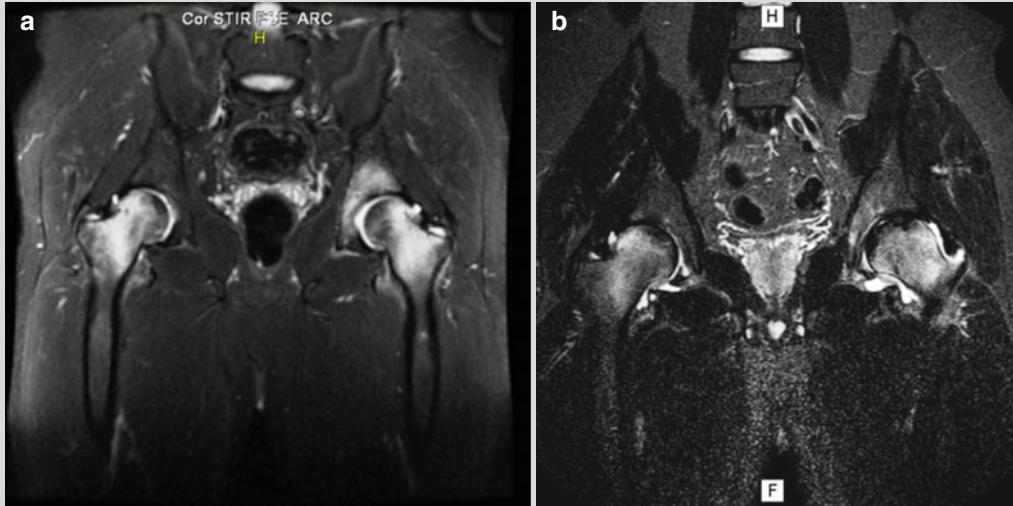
(a) Notice the left-sided acetabulum and proximal femur regions' bone marrow edema (fat-suppressed T2-weighted coronal image). This scan was obtained at the beginning of bisphosphonate treatment.
